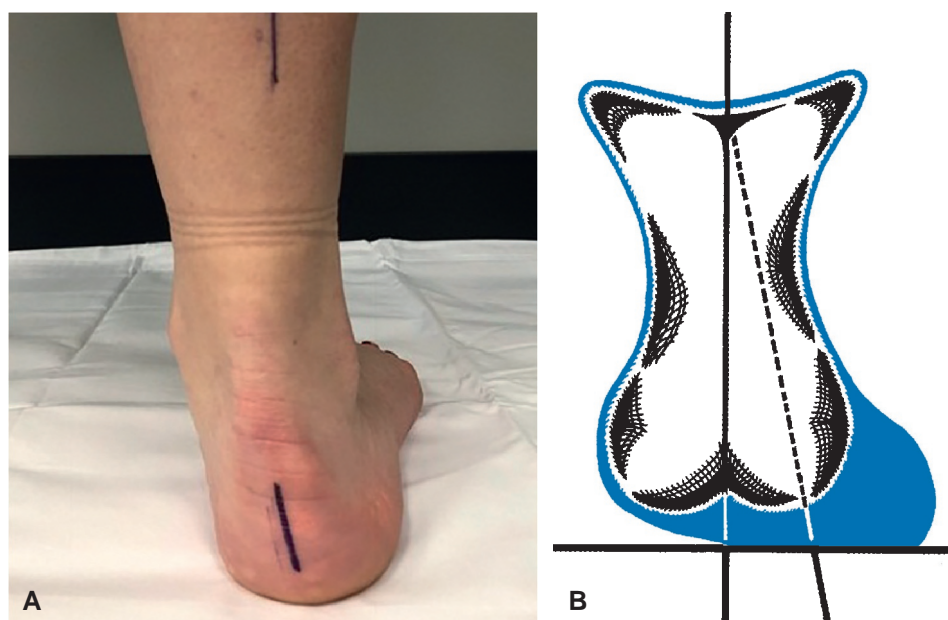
(A) Calcaneal alignment to floor. (B) Lateral migration of the infracalcaneal fat pad can give the illusion of an everted calcaneal to floor alignment. (Courtesy Stride, Inc., Middlebury, CT.)
